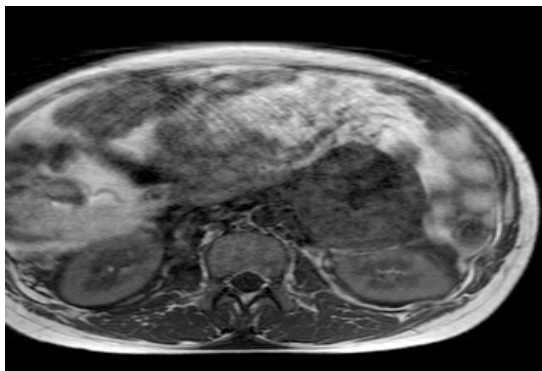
MRI Abdomen and pelvis.
